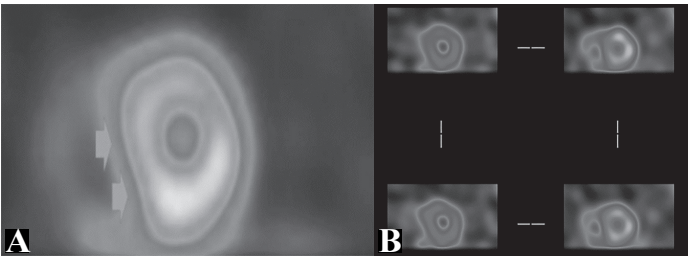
A. Stress perfusion (arrows) and B. stress-gated SPECT images revealed a D-shaped LV (Movahed's sign) morphology with flattening and stretching of the interventricular septum in both the ED (left column) and ES (right column) stages; the right ventricle was also observed in the right column because of the patient's history of right heart failure
